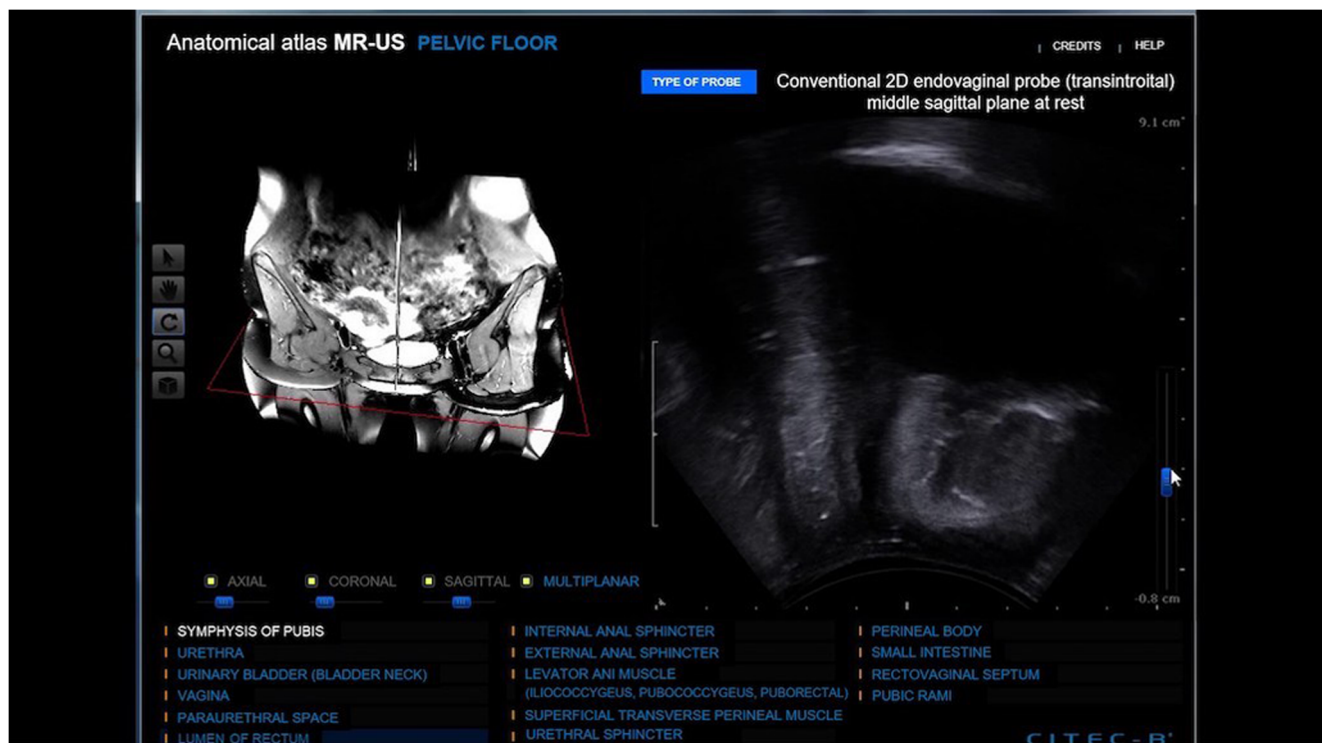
Images of NMR and ultrasound are shown simultaneously
